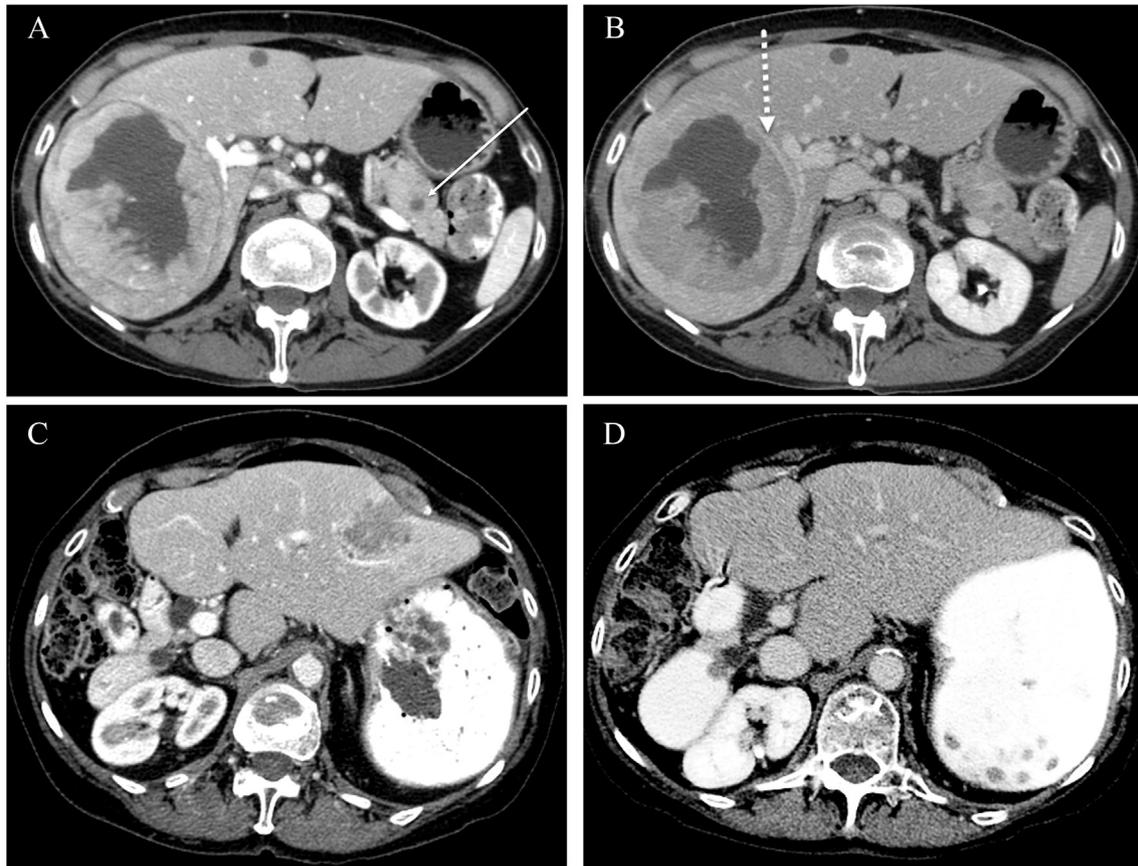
Abdominal CT scans at diagnosis demonstrate the A) pancreatic tail mass with small cystic change (arrow) and the dominant hypervascular hepatic metastasis with B) washout and pseudocapsule (dashed arrow) on delayed imaging. Three years later, C) recurrent tumor was identified in the liver with D) subsequent complete response to therapy.
